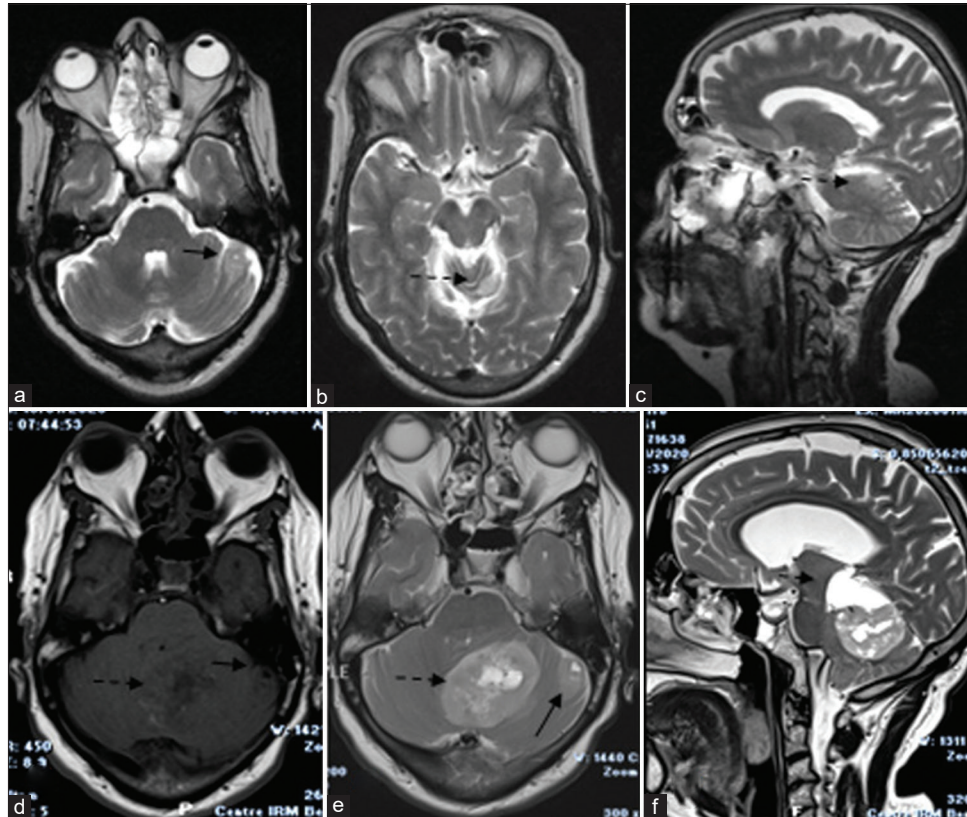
Brain magnetic resonance images (MRI) of the second case. (a and b) T2-weighted images in axial and (c) sagittal section of the first scan 10 years ago performed for a transient ischemic stroke, showing an incidental finding of two cerebellar masses, one in the upper vermis (dash arrow) and the second in the left hemisphere (arrow). Pre-operative MRI: (d) Axial T1 and (e) axial T2 and (f) sagittal T2 images showed important enlargement of the vermian mass (dash arrow), while the left hemispheric one did not significantly grow (arrow).
